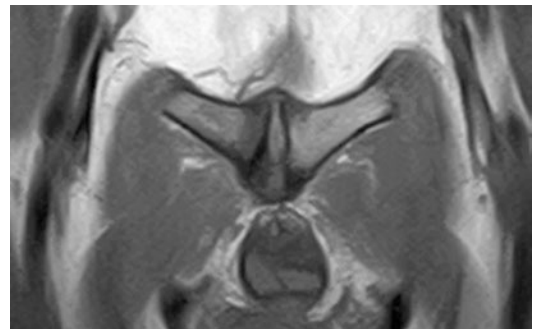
MRI coronal T1. The image shows a bulge of the symphysis central disc with signs of pubic arthropathy
